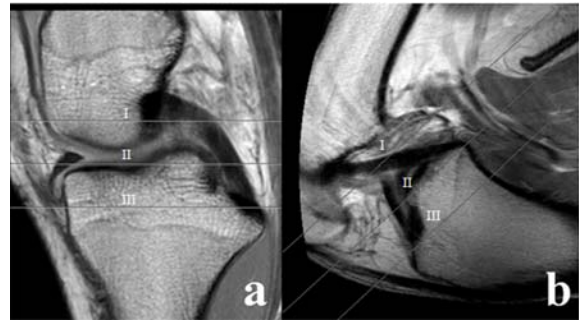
Sagittal MRI of the knee during extension (a) and flexion (b); showing the measurement plane at 1 cm above joint line level (I), at joint line level (II) and at 1 cm below joint line level (III).
